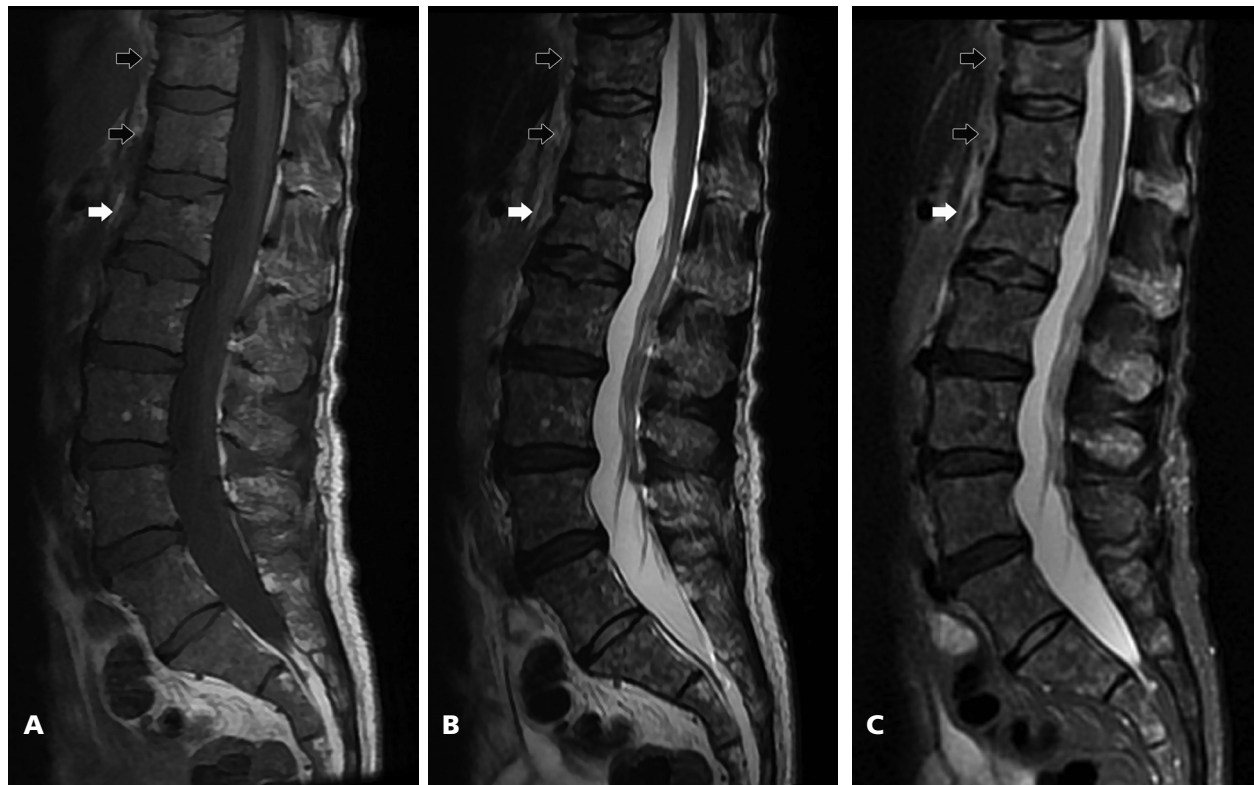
Imaging of the patient's lumbar spine 5 weeks prior to presentation, including (A) lumbar MRI T1, (B) lumbar MRI T2, and (C) lumbar MRI STIR sequences. This MRI was performed during a follow-up to the ED visit approximately one week later. The L1 vertebra (light arrow) has a very clear new wedge fracture. However, there is no formation of BME indicating an acute event. This result was read as chronic by the radiologist, and no interventional treatment was performed. Diffuse abnormal bone marrow signal changes and enhancement are seen, a development consistent with MM. The T11 and T12 (dark arrows) vertebrae are visible in these sections and do not demonstrate vertebral body fractures at this time.
